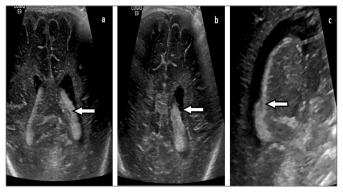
(a) Hypoechoic line (arrow) dividing the left choroid plexus in two, was seen in axial transfontanel ultrasonography section. (b) Thickening of the left choroid plexus and choroid plexus cyst (arrow) were observed in axial transfontanel ultrasonography section. (c) Lobulation in the left choroid plexus (arrow) was seen in sagittal transfontanel ultrasonography section.
